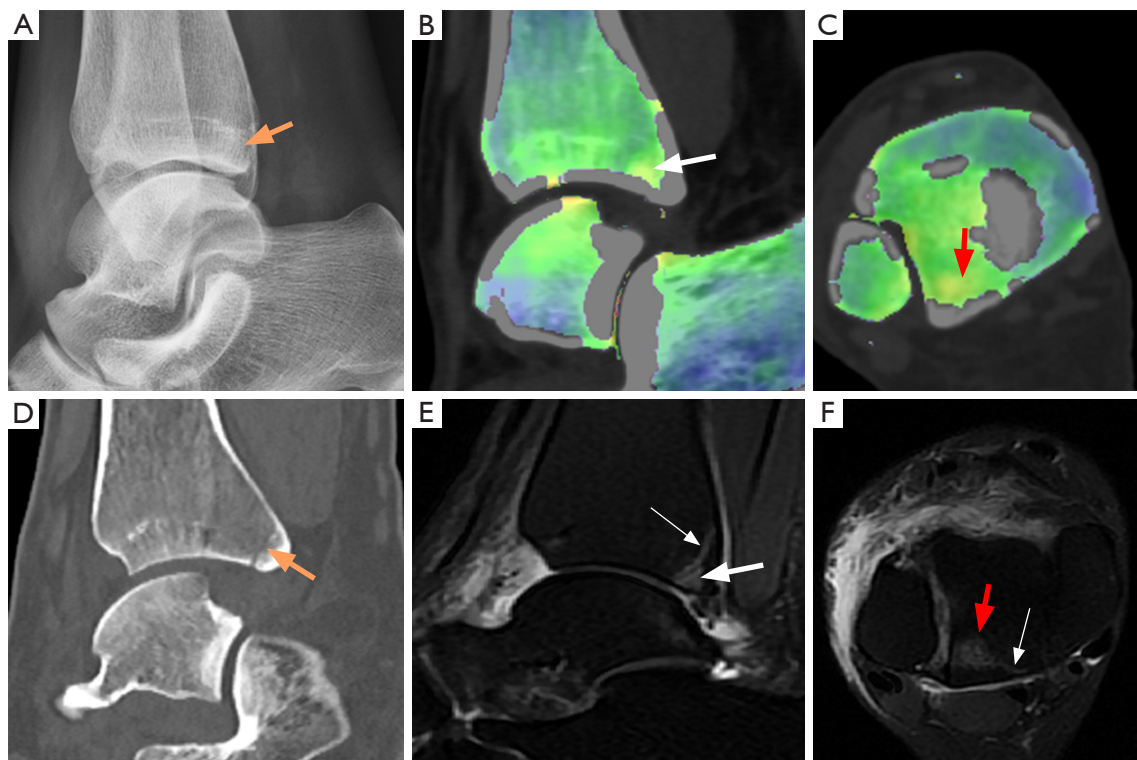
Images of a 37-year-old female who twisted her right ankle while descending stairs. X-ray radiography, MRI, and DECT were performed at 5, 6, and 8 h after trauma, respectively. (A) No positive results were observed on the X-ray image (orange arrow). (B) The sagittal reconstructions of the DECT color-coded VNCA image of the left posterior ankle revealed patchy yellow areas of BME (white single arrow). (C) The axial reconstructions of the DECT color-coded VNCA image of the left posterior ankle revealed patchy yellow areas of BME (red arrow). (D) Conventional grayscale CT (Br59) showed small and blurry low-density fracture lines (orange arrow) that were difficult to distinguish from vascular grooves. (E) The fracture line (white thin arrow) and axial bone marrow edema (white thick arrow) of the right posterior ankle on the MRI fat suppression images in the sagittal and axial directions. (F) The fracture line (white thin arrow) and axial bone marrow edema (red arrow) of the right posterior ankle on the MRI fat suppression images in the sagittal and axial directions. MRI, magnetic resonance imaging; DECT, dual-energy computed tomography; VNCA, virtual non-calcium; BME, bone marrow edema; CT, computed tomography; Br, bone reconstruction algorithm.
